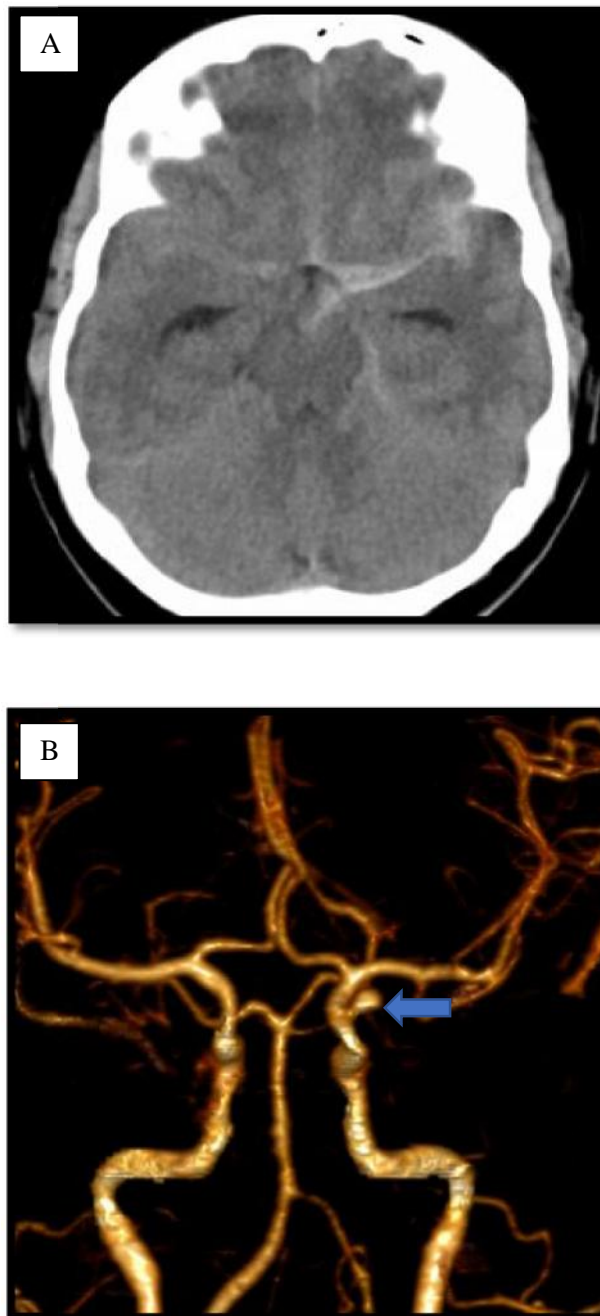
55year female patient with sudden onset severe headache. (A). unenhanced CT showing diffuse subarachnoid haemorrhage, Fisher's revised grade 3. (B) Anterior VRT showing a saccular aneurysm at the supraclinoid segment of the left ICA.
